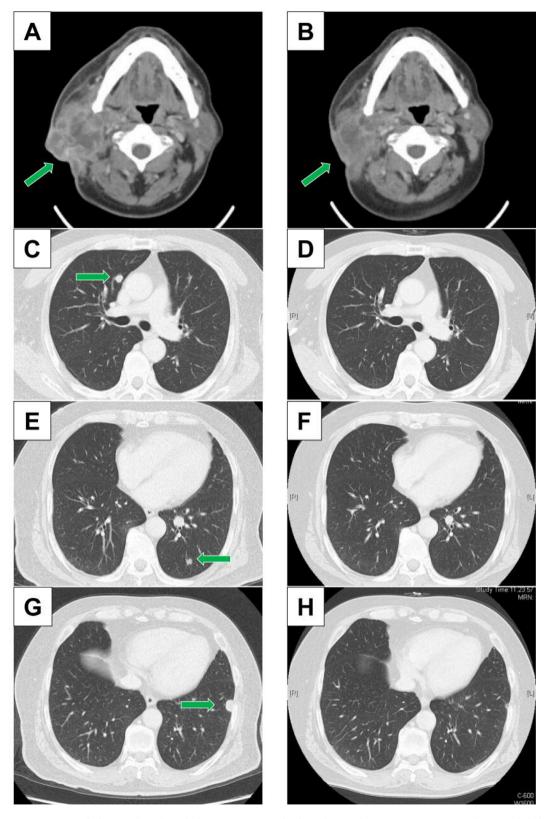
Representative images before (A, C, E, G) and after (B, D, F, H) carboplatin/docetaxel treatment in a patient with myoepithelial carcinoma. Post-treatment computed tomography scans revealed a partial response of the primary lesion and a complete response of all pulmonary metastatic lesions. The green arrows indicate the primary lesion (A, B) and lung metastases (C, E, G).
